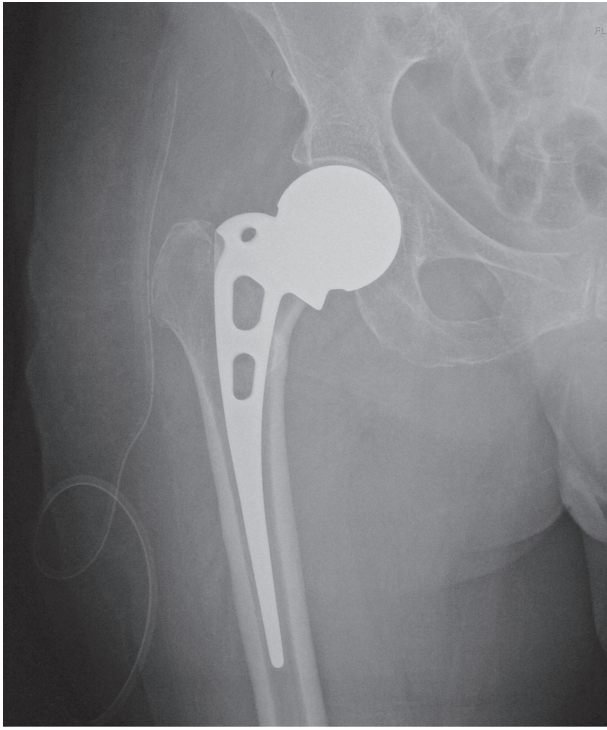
Postoperative radiograph hemiarthroplasty.
